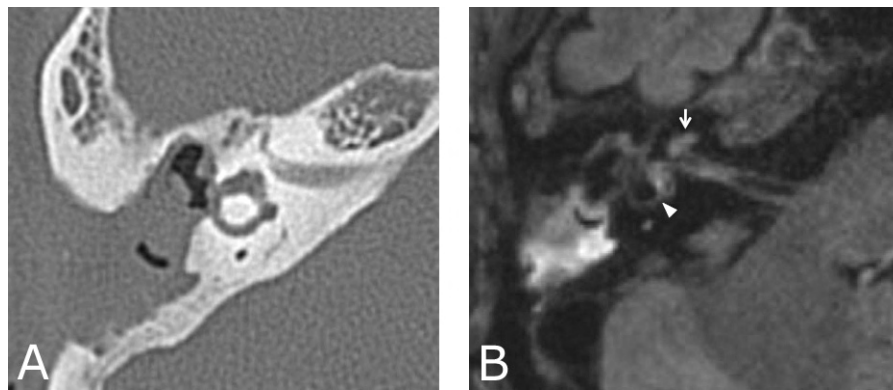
Example images of CT (A) and 3D-FLAIR MRI (B) in a case with a labyrinthine fistula in the lateral semicircular canal. High signals in the lateral semicircular canal (arrowhead in B) and in the cochlea (arrow in B) of the affected ear.
